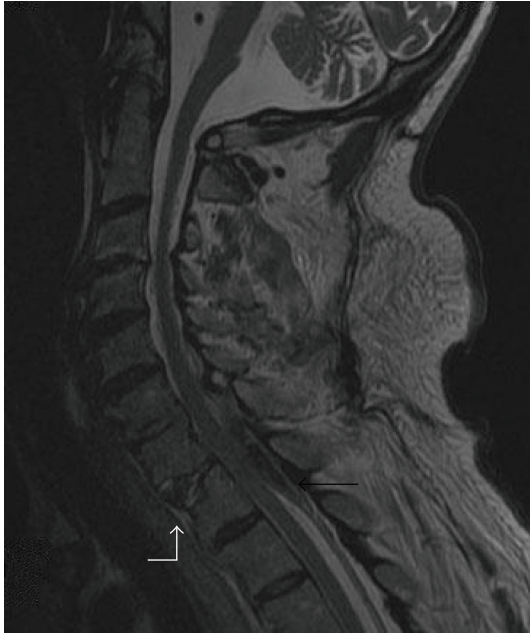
Sagittal magnetic resonance imaging delineating a posterior epidural hematoma (black arrow) accompanying a cervicothoracic fracture dislocation (white arrow).
